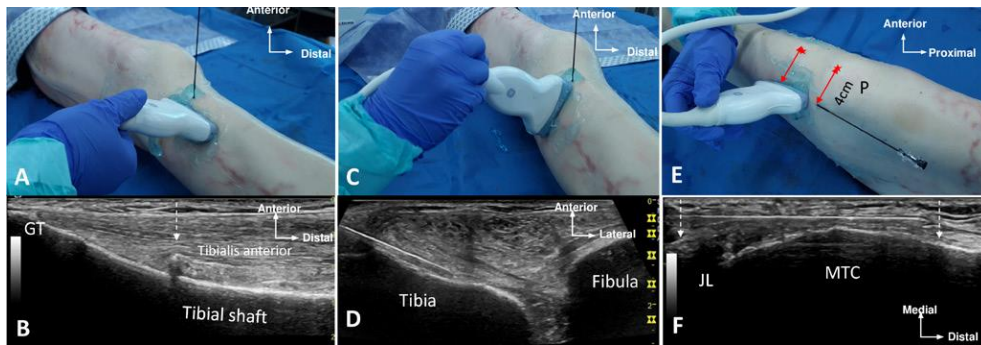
Cannula placement and US landmarks for RFN and IPBSN in the cadaveric knee. (A, B) Coronal plane: target point for RFN. (C, D) Axial plane: final position of the RF cannula for the RFN. (E, F) Coronal plane: RF cannula placement on the treatment line for the IPBSN. Red stars indicate the patella apex and tibial tuberosity; vertical dashed arrows indicate the target levels on US view. GT, Gerdy's tubercle; IPBSN, infrapatellar branch of the saphenous nerve; JL, medial femorotibial joint line; MTC, medial tibial condyle; RF, radiofrequency; RFN, recurrent fibular nerve; US, ultrasound.
